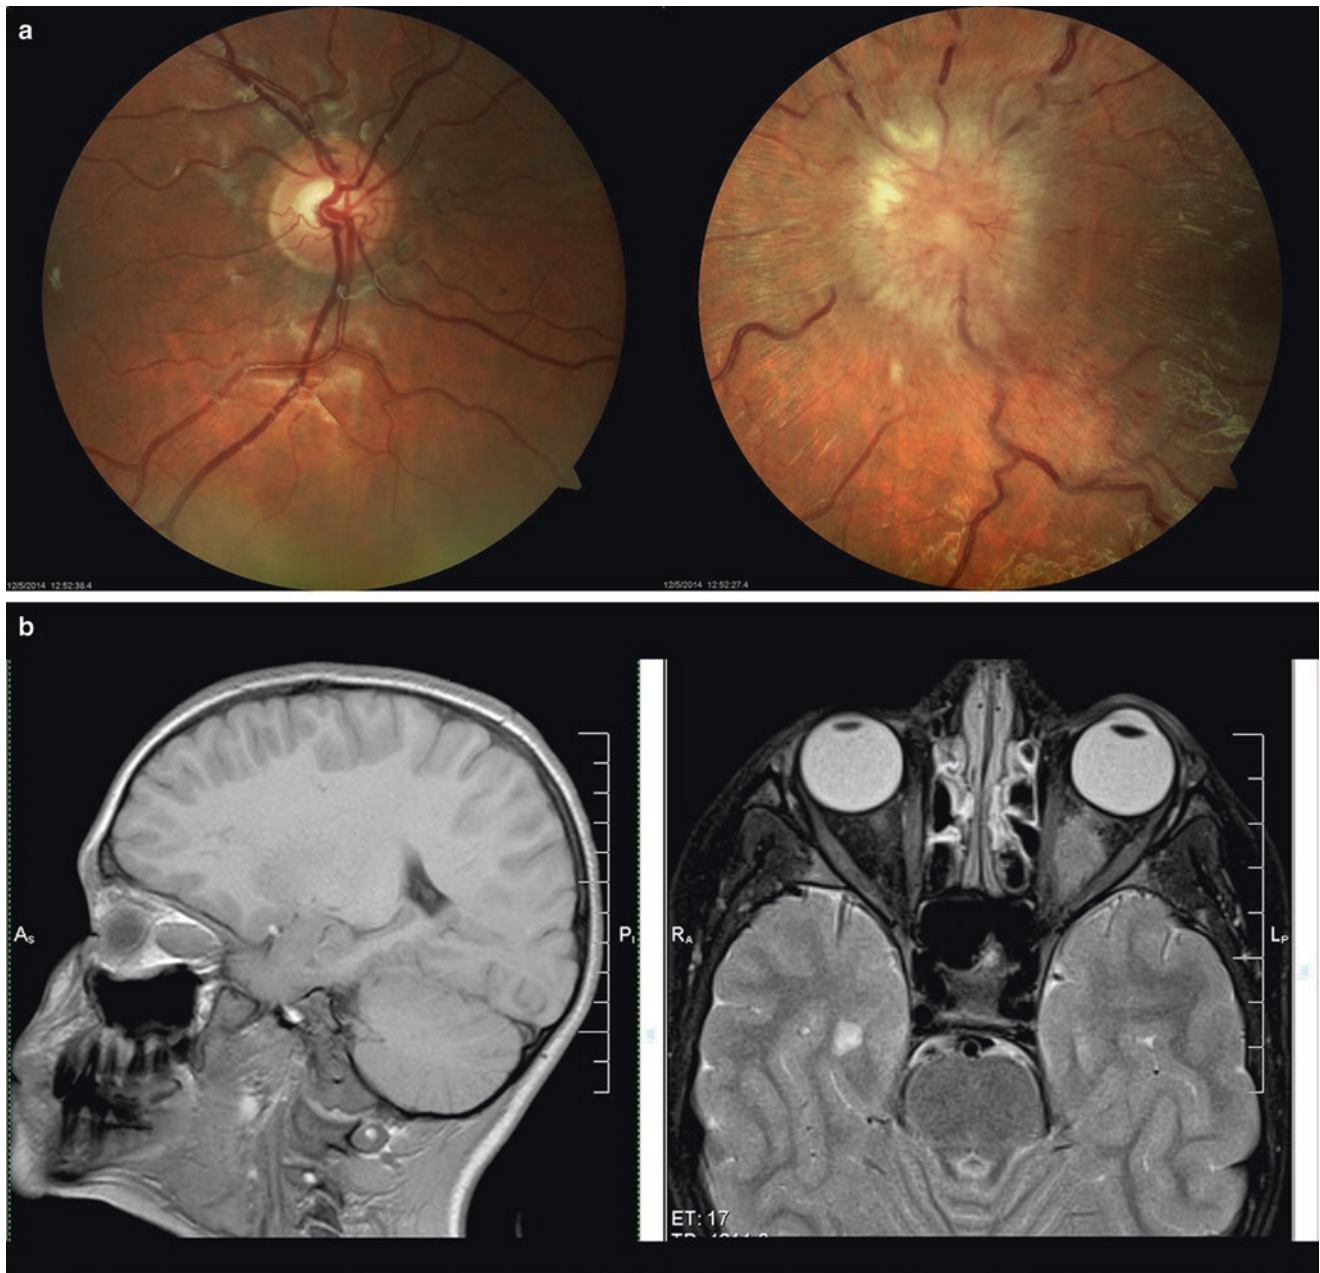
(a) Normal optic nerve on the left (*right eye*) and leukemic infiltration of the optic nerve on the right (*left eye*). (b) Magnetic resonance image of optic nerve. Note enlarged optic nerve and sheath on the left due to leukemic infiltration
